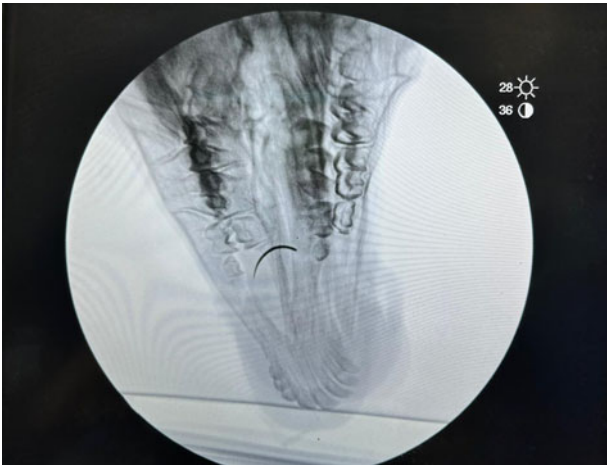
X-ray of a lamb's head with a surgical needle fragment in its tongue.
